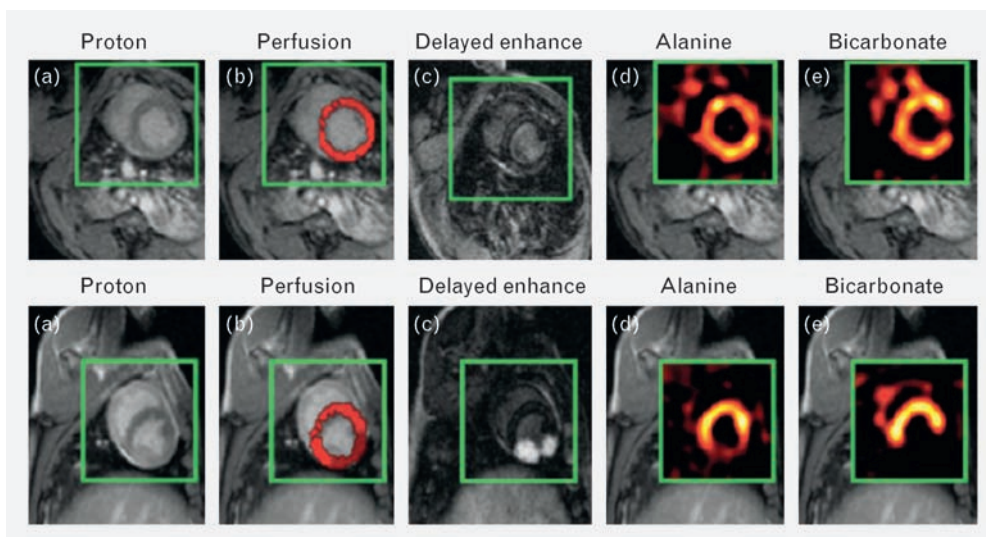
Myocardial images obtained using hyperpolarization-enhanced ^{13}C magnetic resonance imaging after 15 min (top row) and 40 min (bottom row) of occlusion of the circumflex artery. (a) Proton (^1H) NMR images. (b) Semiquantitative gadolinium-enhanced perfusion maps. (c) Delayed gadolinium-enhanced images showing myocardial fibrosis. (d, e) Mapping of alanine (d) and bicarbonate (e). (Modified from Golman [23]).
